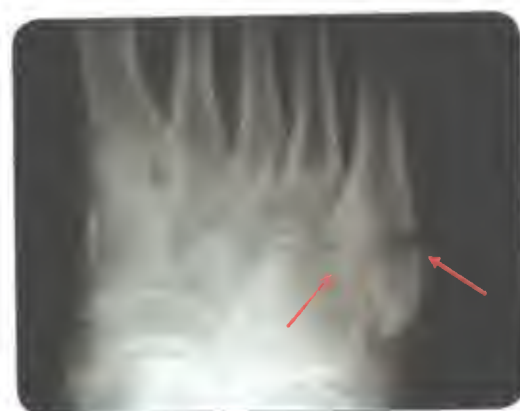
Radiograph of a Jones' fracture
